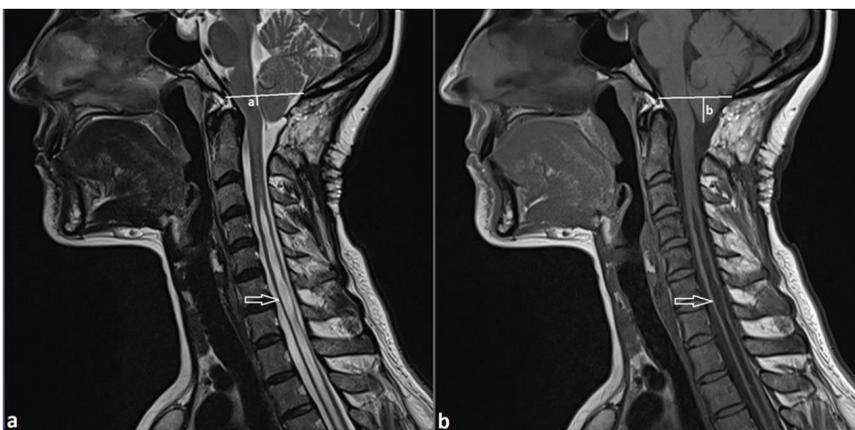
The presence of syringomyelia (arrow), (a) the distance of obex (a marker for the cervicomedullary junction, where the fourth ventricle becomes the central canal in the cervical spinal cord) measured in mm according to the McRae line (a line extending from Basion to Opistion), and (b) the distance of the cerebellar tonsils were assessed from cervical spinal MRI images. Measurements performed above the McRae line were evaluated as negative values, while measurements performed below were considered positive.
